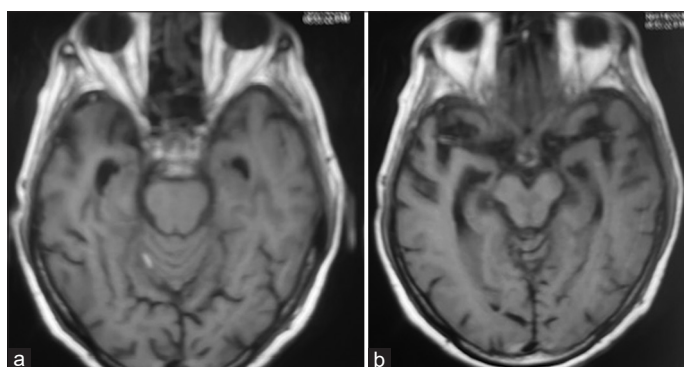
(a) Axial T1 weighted magnetic resonance imaging (MRI) brain image showing hyperintensity over retroclival region. There is mild subarachnoid hemorrhage over right cerebellar folia; (b) MRI brain T1 weighted image showing normal peri-mesencephalic and suprasellar cisterns
